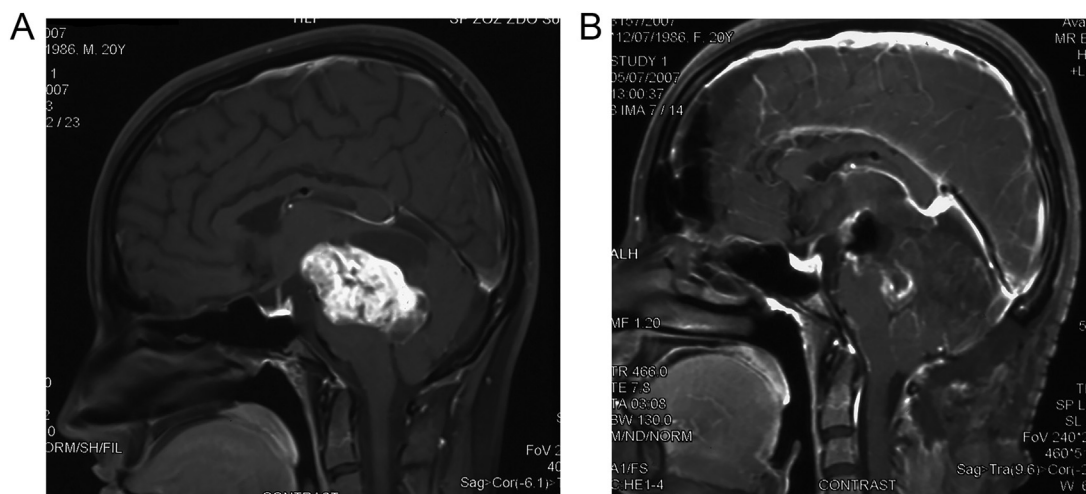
(A and B) MRI of a patient with a tumour of the mesencephalon and the pons (sagittal section) before and after surgery. Total tumour resection.
